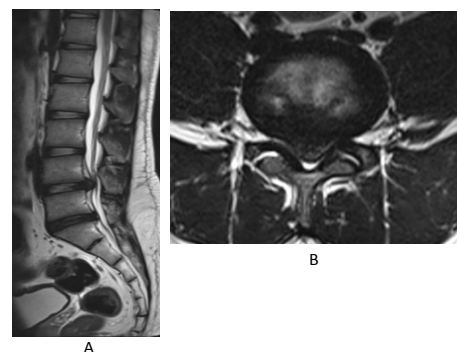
Pre op sagittal and axial MRI pictures showing a large central disc at L4-5 level causing severe stenosis of the neural canal and severely compressed thecal sac.
